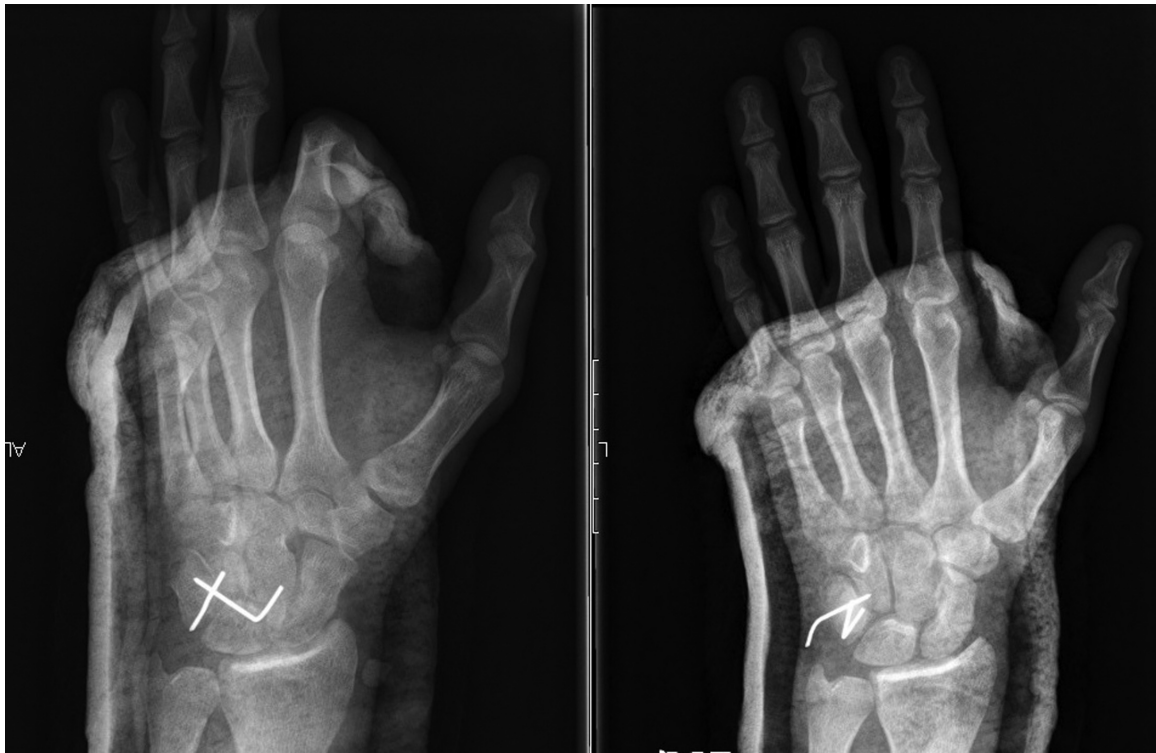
Immediate postoperative radiograph demonstrating the anatomical reduction of the pisiform and its fixation to the triquetrum bone with Kirschner wires.
